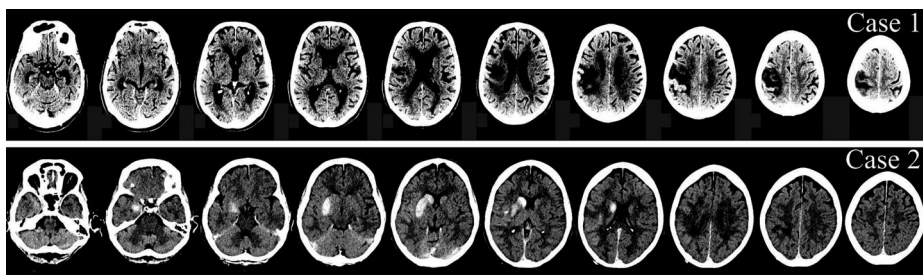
Multislice head CT images of Case 1 and 2. The images show axial slices of the patients' brains. Per individual, slices were selected to enhance visibility of the lesions.
